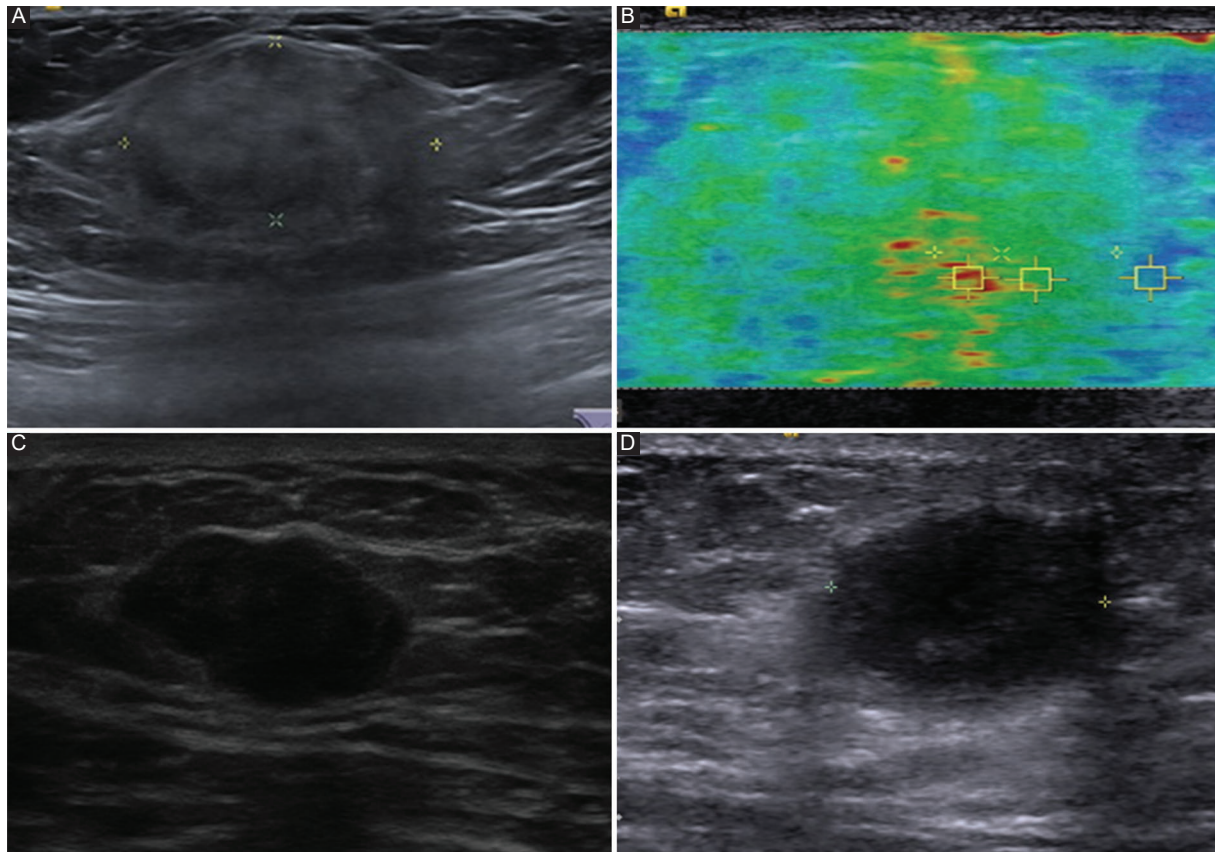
Características ultrasonográficas y por elastografía de lesiones benignas de mama en los hombres. A: ultrasonido que muestra una lesión con características de nódulo isoecoico con bordes bien delimitados. El reporte histopatológico fue compatible con un miofibroblastoma. B: elastografía que muestra la solidez del tejido, el cual fue auxiliar para integrar el diagnóstico junto al reporte histopatológico final que indicó un miofibroblastoma. C: ultrasonido que muestra una lesión en la mama con características de nódulo hipoeicoico con bordes irregulares, más ancho que alto, el cual resultó ser un fibroadenoma. D: ultrasonido que muestra una lesión en la mama, con presencia de un nódulo hipoeicoico de bordes bien delimitados, cuyo estudio histopatológico reportó como fibroadenoma.
